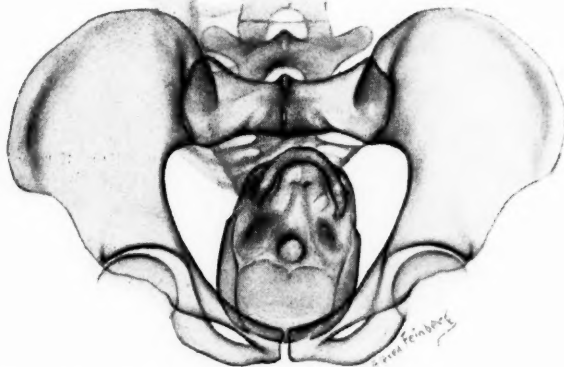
Third x-ray examination in labor (same case as Figs. 7 and 8). With further descent through the fore-pelvis the head has rotated almost to a direct O. A. position at the level of the spines.
